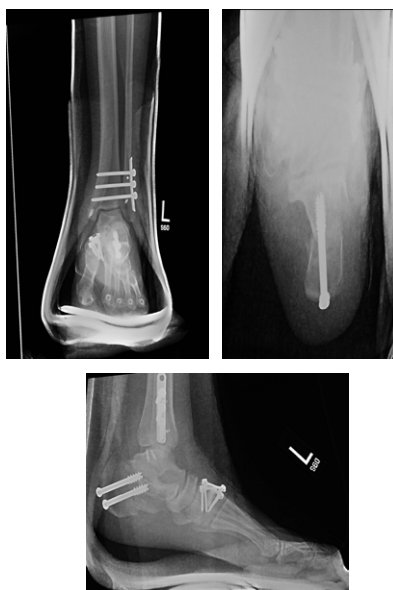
Postoperative Radiographs, Internal Fixation of the Syndesmosis.
